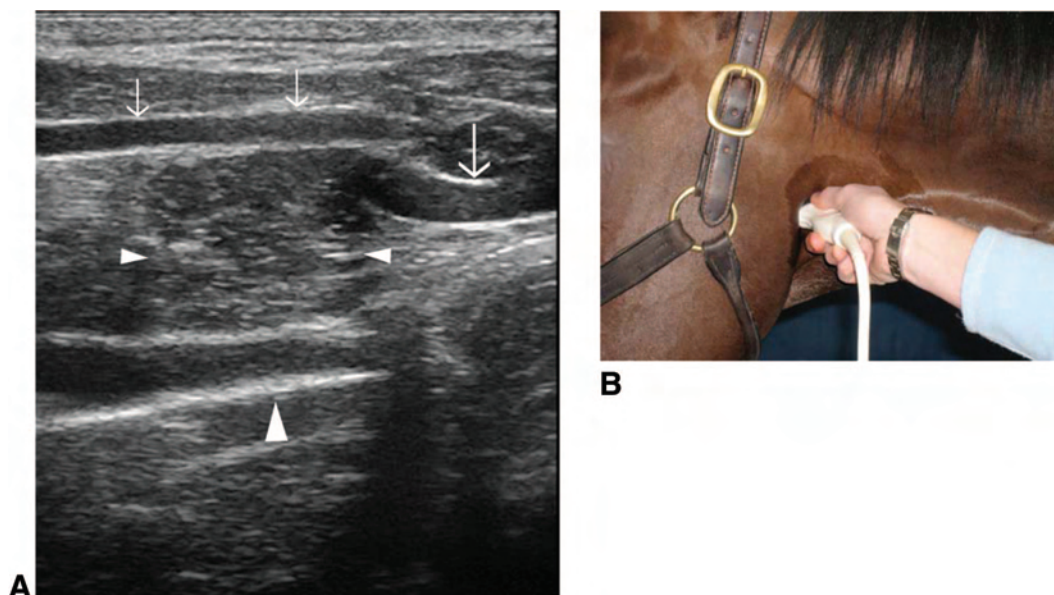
Dorsal plane ultrasound image of the lateral aspect of a normal larynx (A). Transducer position is shown in B. Note the position of the cricoarytenoideus lateralis muscle (small arrowheads) between the thyroid cartilage (small arrows) and the arytenoid cartilage (large arrowhead). The cricoid cartilage (large arrow) is caudal to the thyroid cartilage. Rostral is to the left of the image and caudal is to the right of the image.
